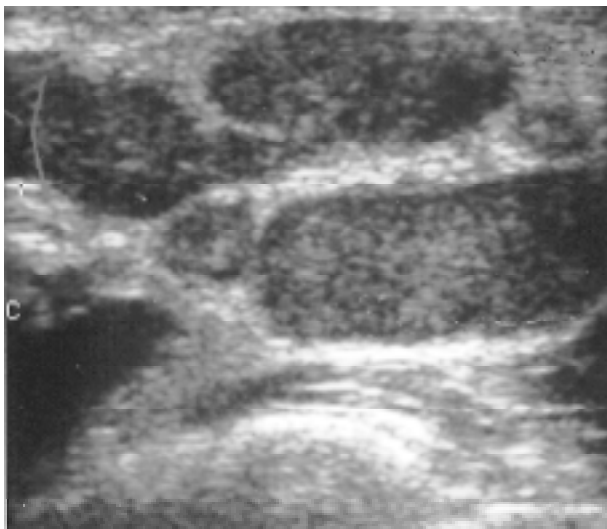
Mesenteric adenitis: enlarged hypoechoic mesenteric lymph node; power Doppler shows inflammatory hypervascularization within the lymph node.
